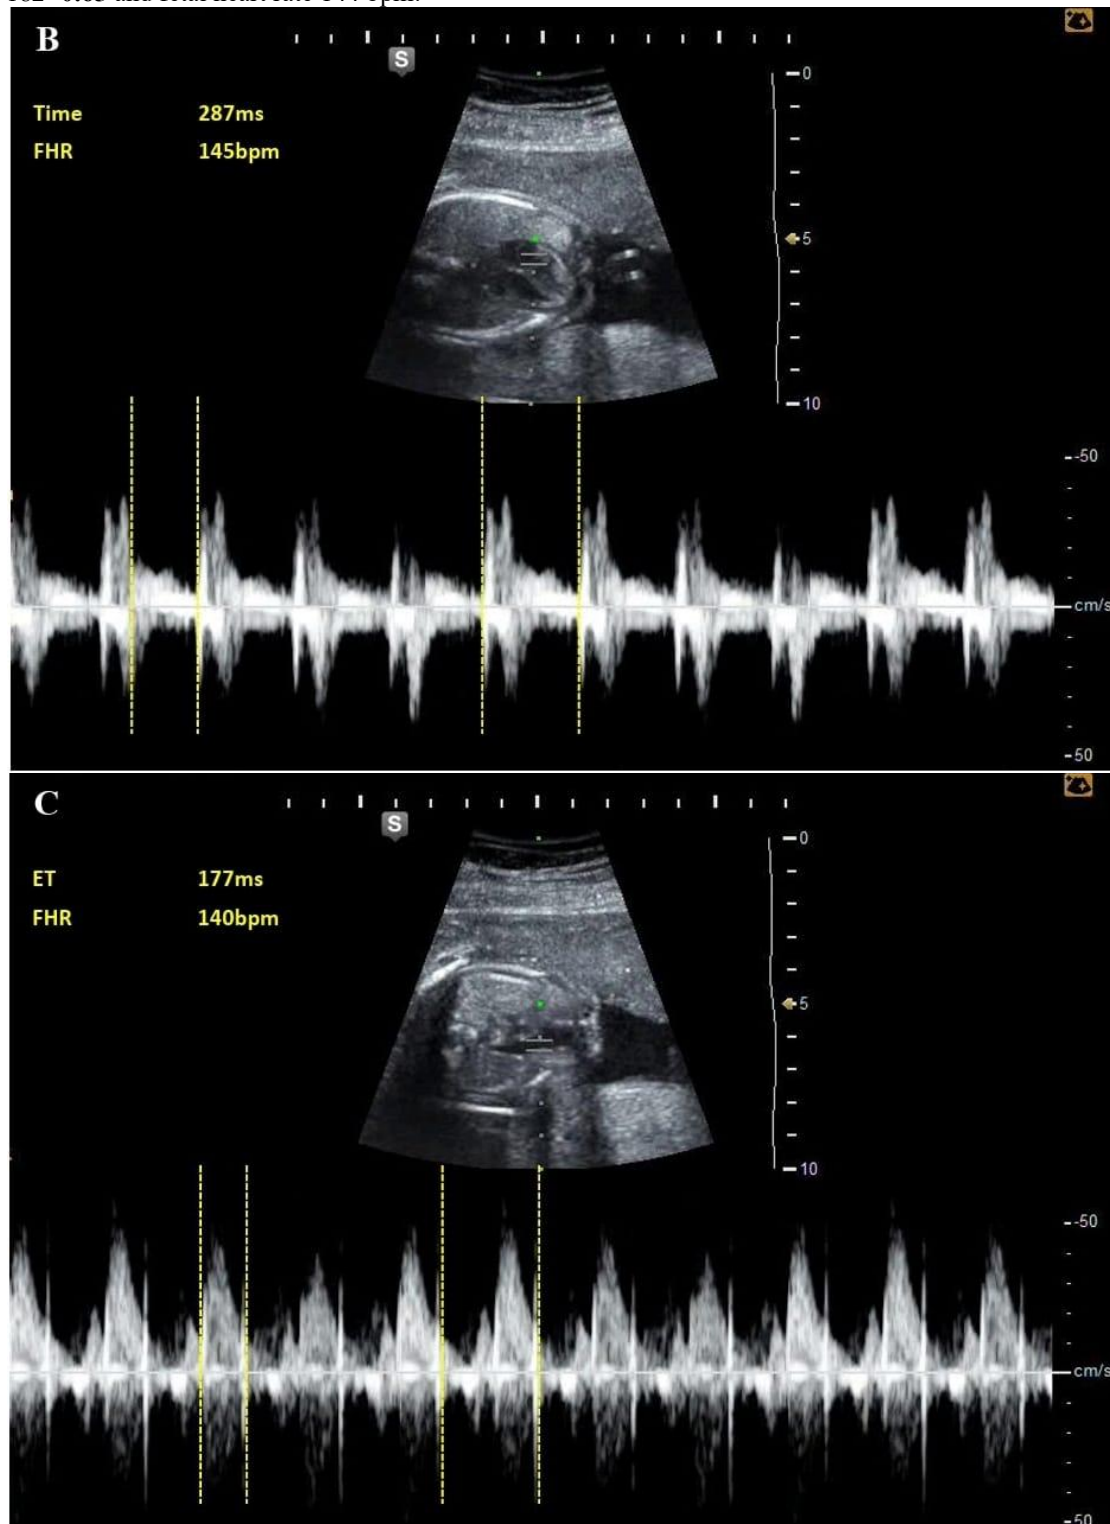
Measurement of right ventricular (MPI) using pulsed wave Doppler at the tip of tricuspid leaflets and measure (a) time interval from closure to aperture click of the tricuspid valve as shown in (B) and just below the PV (b) time interval between the aperture and the closure of the pulmonary valve was measured in (C) then MPI was calculated with following way $(a-b)/b$, so high Tei index of RV $(287-177)/177=0.62$ with fetal heart rate 140-145 bpm.
